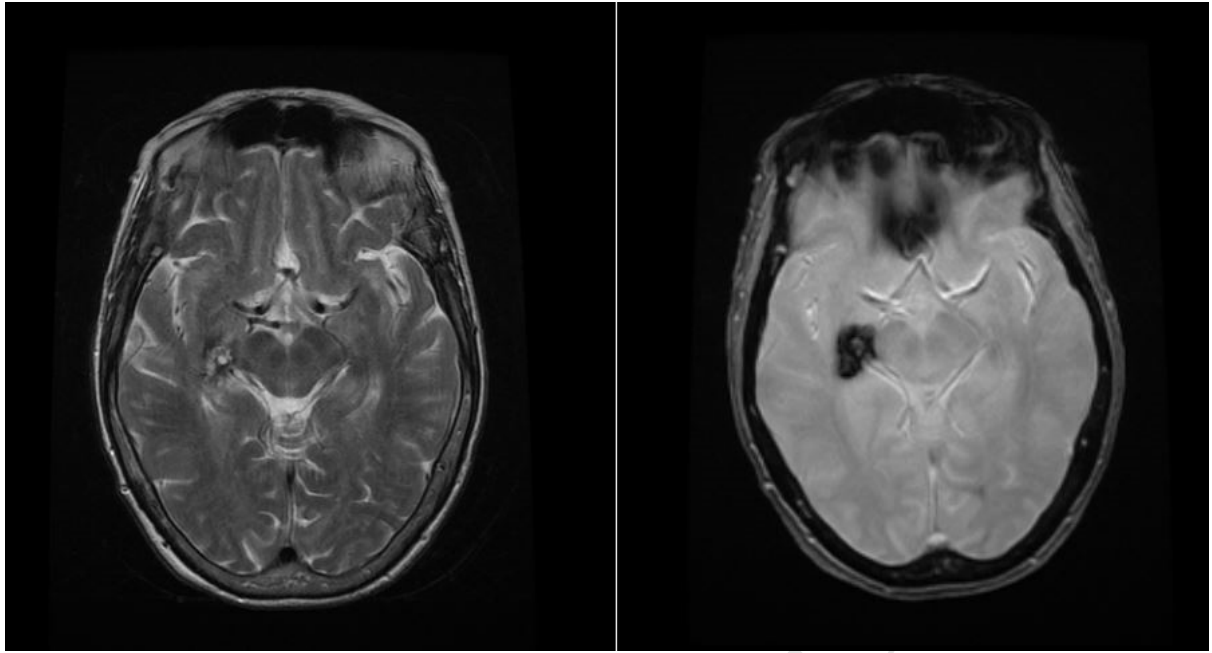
Interval MRI in June 2013 showing no significant changes in appearances compared to the initial MRI.
